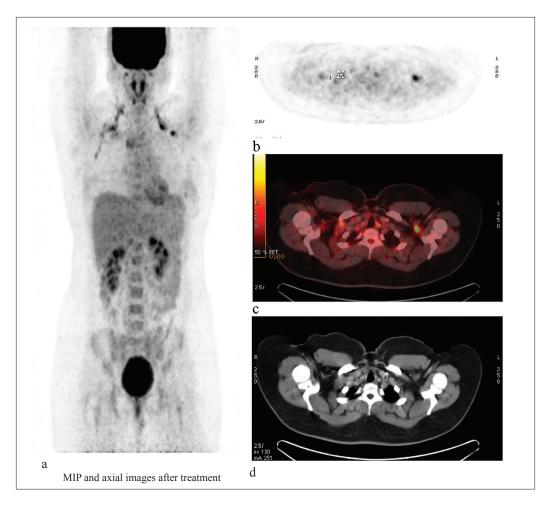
Repeat FDG PET/CT examination during the follow up at 6 months interval upon completion of the anti-TB treatment revealed partial and complete metabolic remissions of the previously active lesions. On CT, these lesions were smaller, i.e. less than 1 cm in diameter with no significant enhancement pattern following the intravenous contrast administration
